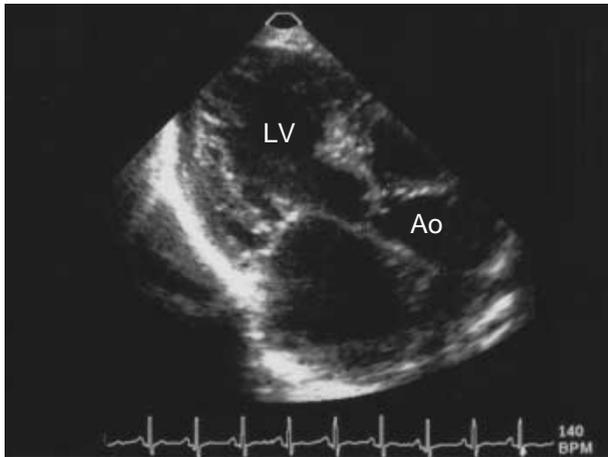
The echocardiography shows aortic stenosis and post-stenotic dilatation, measuring 1 cm and 1.74 cm, respectively. Ao, aorta; LV, left ventricle.
